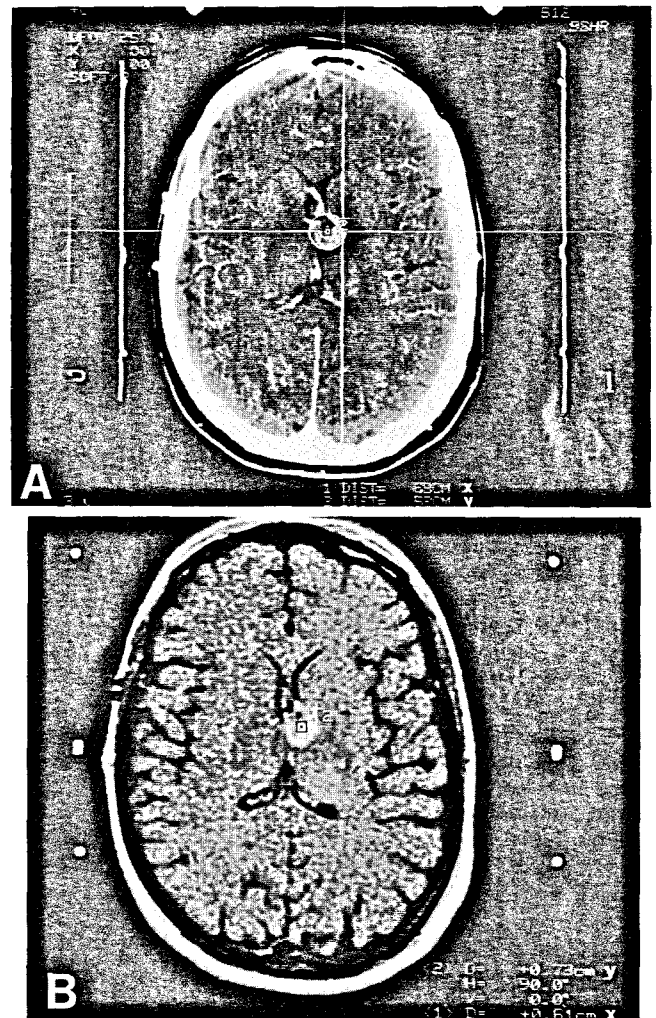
Axial CT image with contrast enhancement (A) and T1-weighted spin-echo MRI study with gadolinium diethylene-triamine-pentaacetic acid (B) show an anaplastic astrocytoma of the internal capsule and thalamus at the time of the stereotactic biopsy. The center of the square marks the target coordinate used in comparing the two techniques.
